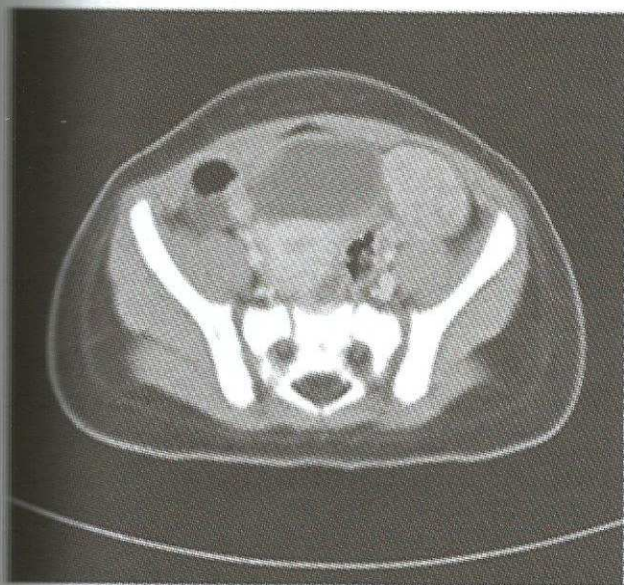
CT scan of pelvis showing lobulated mass in left adnexal region.
